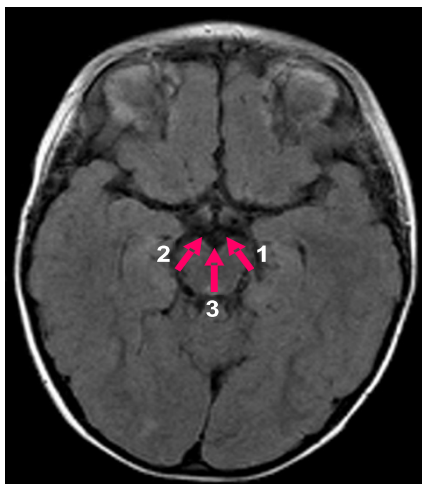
Axial T1-weighted images. Axial diameter of the cerebral peduncles (left arrow number 1) and right (arrow number 2). Axial diameter of the midbrain (arrow number 3).
